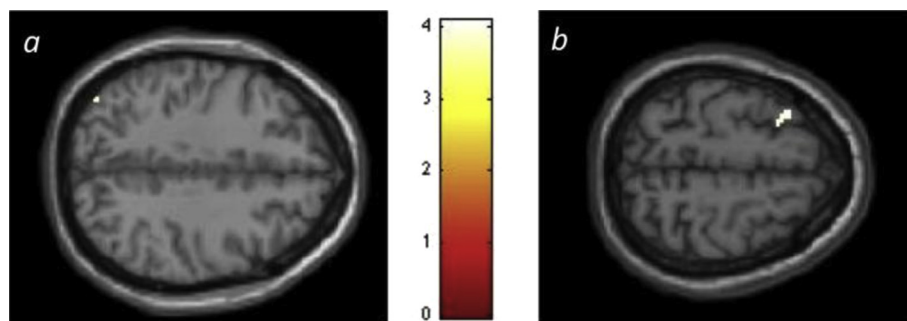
Higher ceilings activated the precuneus and middle frontal gyrus in beauty judgments. Notes. (a) precuneus (located adjacent to the occipital gyrus and superior parietal lobule); (b) middle frontal gyrus. SPM rendered into standard stereotactic space and superimposed on to transverse MRI in standard space. Bar represents magnitude of T-score.
